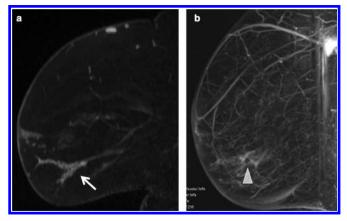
79-year-old female underwent screening MRI, sagittal T_1 -weighted contrast-enhanced image (A) showed a 2.6 cm non-mass enhancement (NME) linear distribution with clumped internal enhancement (arrow). Maximum intensity projection (MIP) of post MRI-guided vacuum-assisted breast biopsy (B). Susceptibility artefact from the biopsy clip is present (arrowhead). The pathology result was atypical ductal hyperplasia and excision yielded to intermediate grade ductal carcinoma *in situ*.
